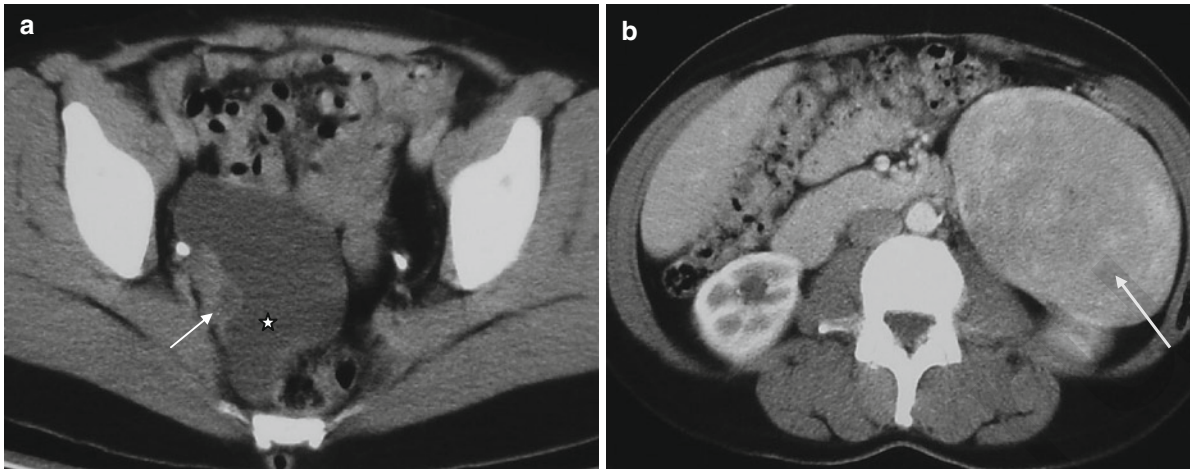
CT recurrent leiomyosarcoma post-hysterectomy and bilateral oophorectomy. (a) Ascitic fluid (*star*) within Pouch of Douglas with peritoneal deposit (*arrow*) adherent to right pelvic
